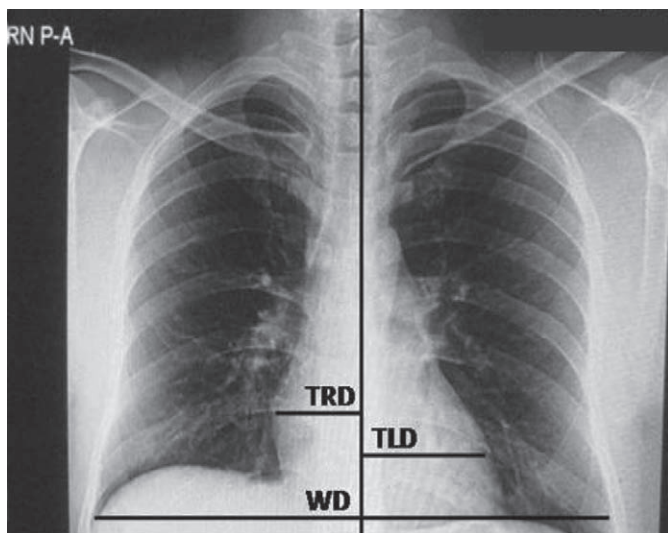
Chest X-ray PA: view showing various diameters of cardiac shadow (TLD: transverse left diameter, TRD: transverse right diameter, WD: widest diameter).
